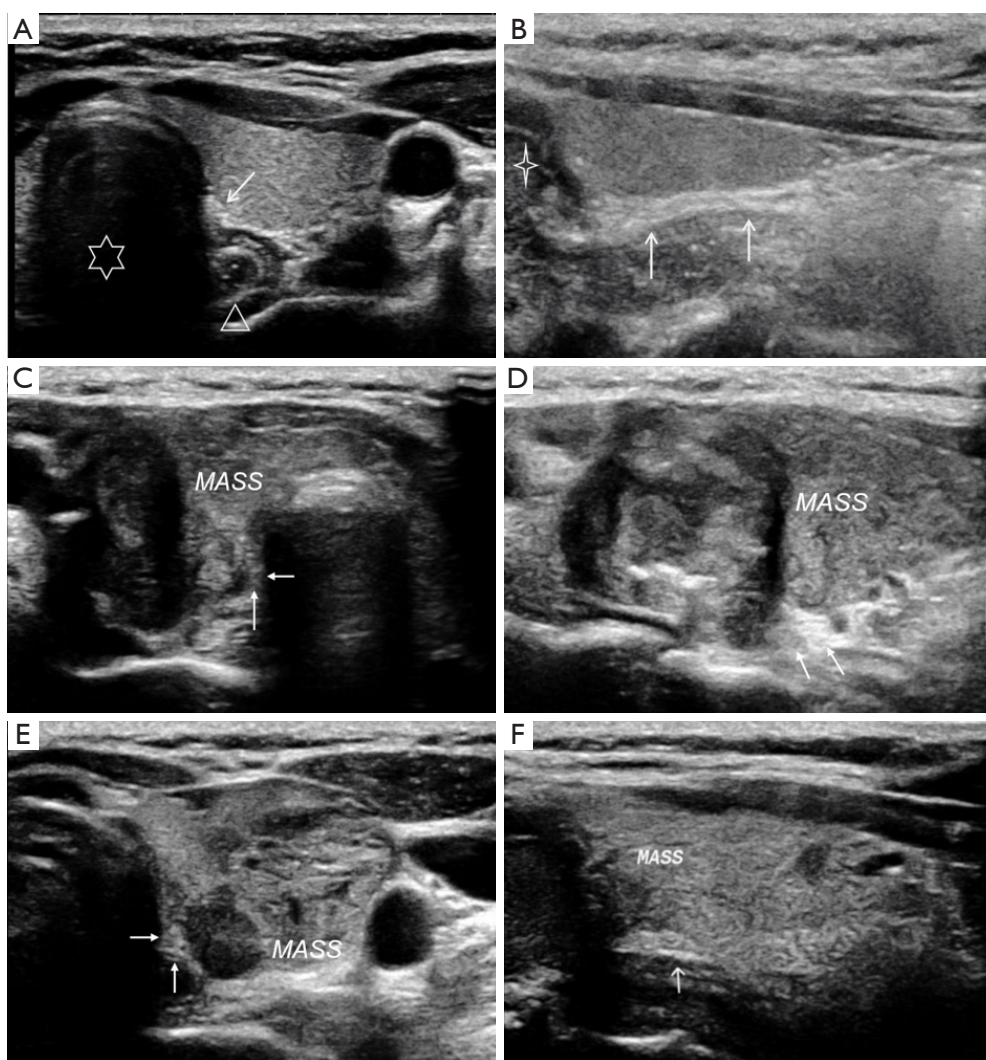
Examples of ultrasound images showing normal and invaded RLNs. (A) Image of a normal RLN along the short axis. (B) Image of a normal RLN along the long axis. (C) Image of an invaded RLN along the short axis. (D) Image of an invaded RLN along the long axis. (E) Image along the short axis of a tumor lying adjacent to the RLN without invading it. (F) tumor adjacent RLN without invasion along the long axis. Arrows indicate the RLN; the six-pointed star indicates the trachea; the triangle indicates the esophagus; the four-pointed star indicates cricoid cartilage; “MASS” indicates thyroid carcinoma. RLN, recurrent laryngeal nerve.
